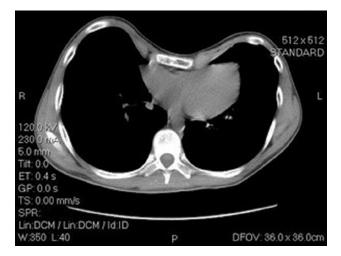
A CT scan of a 14-year-old male with severe PE.
